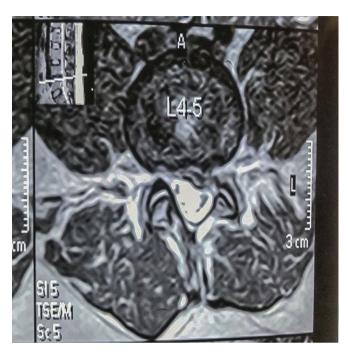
Pre-operative MRI axial section of case 3 showed L4-L5 disc herniation with compression of L4 nerve on the left side.
